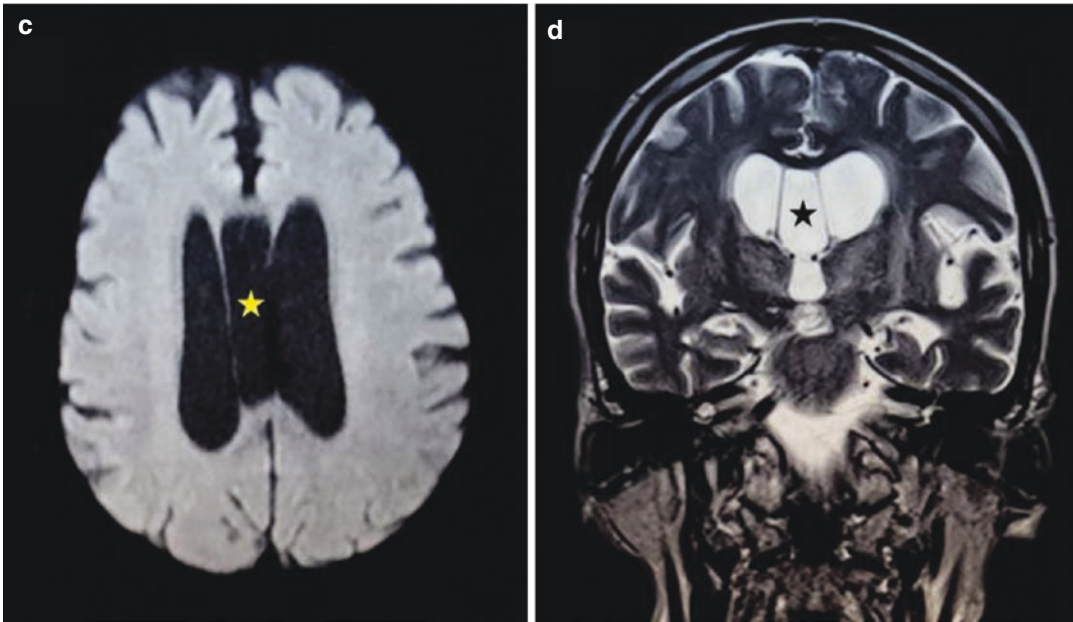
Cavum of the septum pellucidum (arrows) on axial T2-weighted MR image
